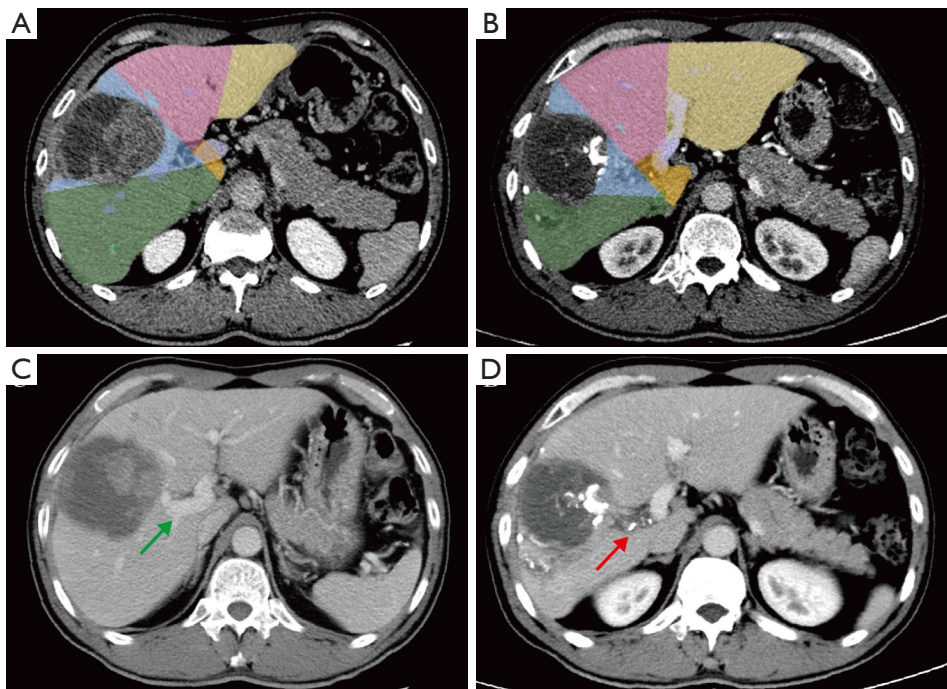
The CT examination showed that the FLR was obviously increased after the first step surgery, while the liver volume of diseased side was decreased. The yellow area shows left lateral lobe, the red area shows the left medial lobe, the blue area shows right anterior lobe, the green area shows right posterior lobe. (A) The 3D reconstruction of CT scan before the surgery. (B) The 3D reconstruction of CT scan after the surgery. (C) The CT scan of the liver revealed filling of the right portal vein (green arrow). (D) The CT scan of the liver revealed complete occlusion of the right portal vein (red arrow). CT, computed tomography; FLR, future liver remnant.
